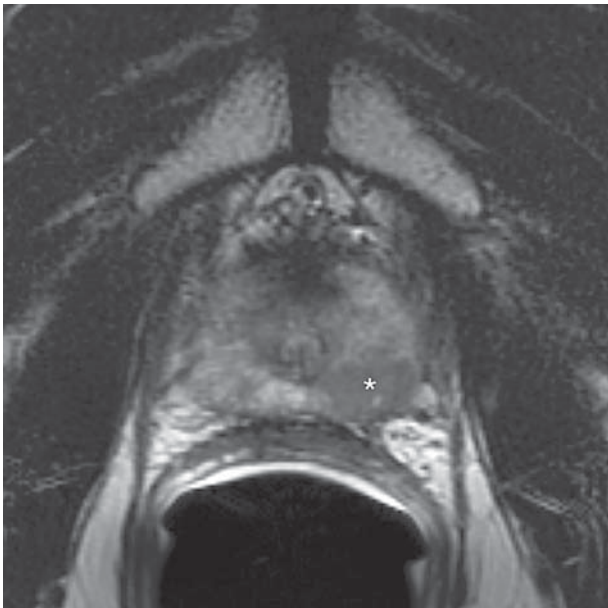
61 year-old man with biopsy-proven recurrence of prostate cancer in the left apex and mid-gland 5 years and 6 months after treatment. Axial T2-weighted image (TE/TR 5000/96) shows a focal nodule of low signal intensity in peripheral zone of the left apex of the prostate (asterisk). Both readers interpreted it as a dominant tumoral lesion in left hemi-prostate.
